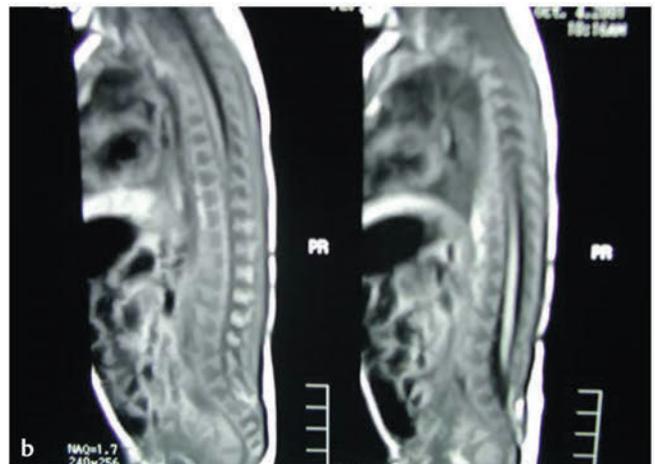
(a) Atretic meningocele in a 9-month-old infant showing the characteristic blue hue. (b) Sagittal T1-weighted magnetic resonance image showing absence of communication between the spinal canal and subcutaneous tissues.
